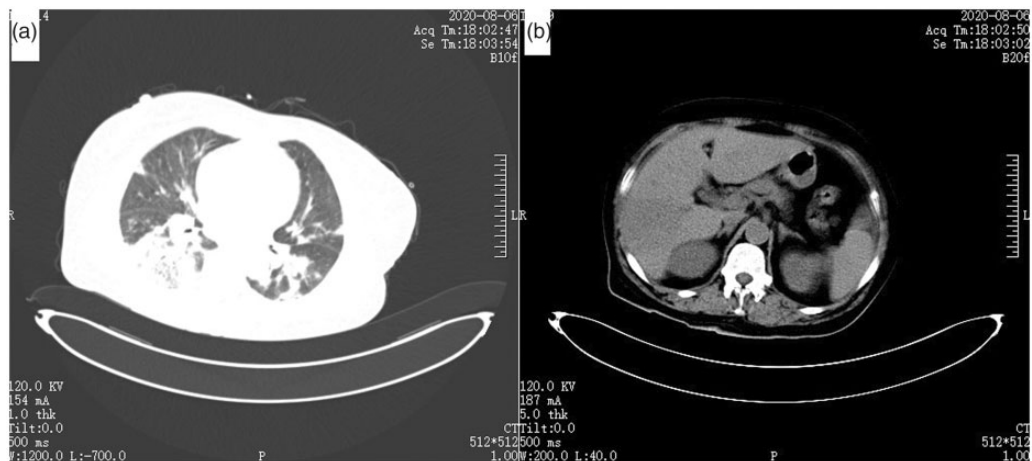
Computed tomography findings of the patient on the first day of admission. CT scan showing bilateral pulmonary infection (a) and a hepatic abscess (b). CT, computed tomography.
